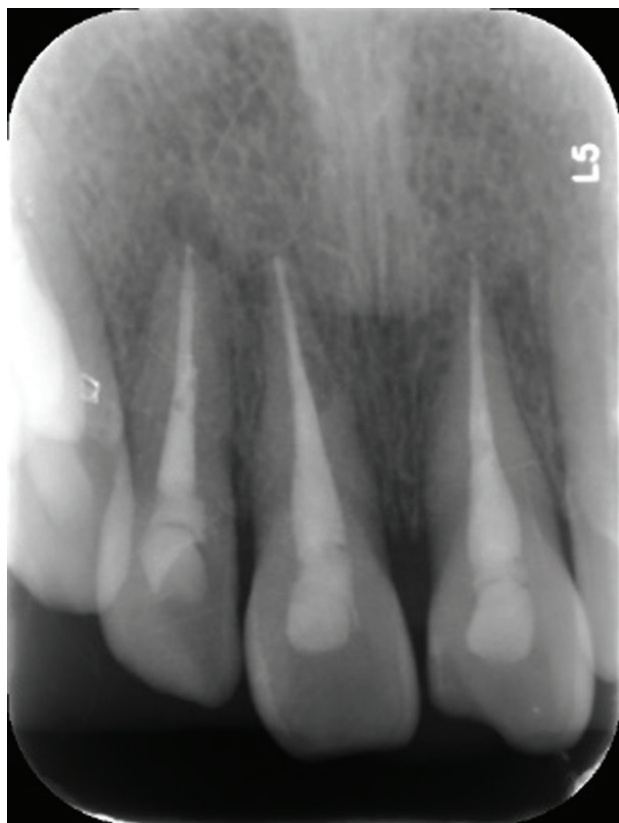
Diagnostic radiograph showing the IRR lesion of teeth 11 and 12.
